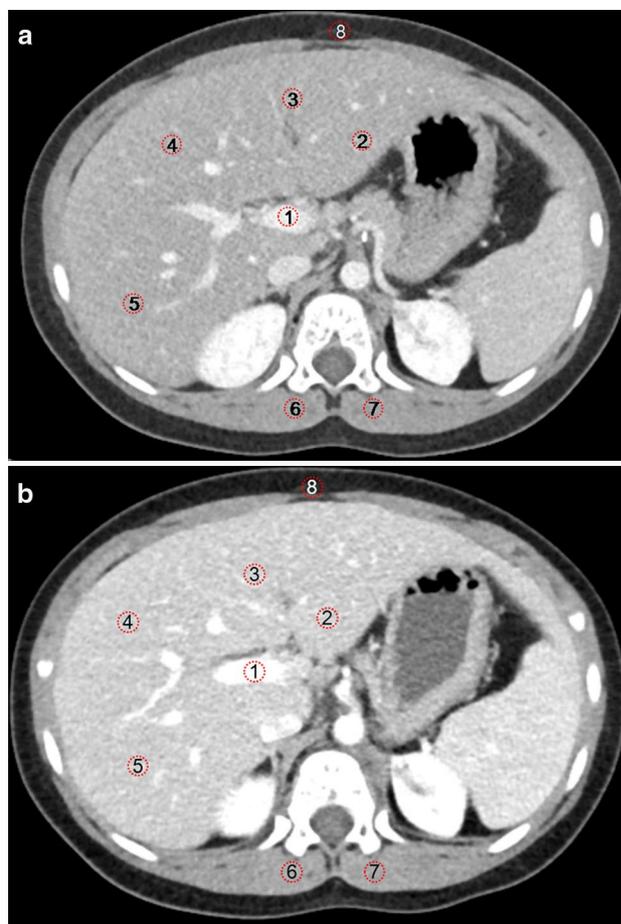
Axial contrast-enhanced portal phase computed tomography (CT) images obtained at different times through different protocols in the same patient (8-year-old girl who underwent a serial follow-up CT after resection of a neuroblastoma). a Standard protocol (80 kVp, 350 mgI/mL) and b double-low protocol (70 kVp, 250 mgI/mL) 3 months later show manually drawn regions of interest (ROIs) on the main portal vein (ROI 1), liver (ROIs 2–5), paraspinal muscles (ROIs 6–7), and subcutaneous fat of the anterior abdominal wall (ROI 8)
